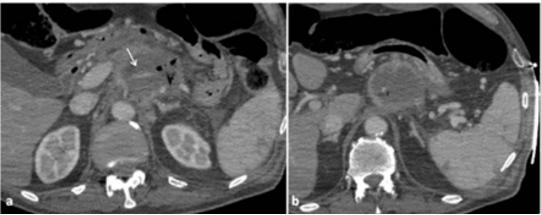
CT scan showed vasoconstriction of splenic artery (a, white arrow) associated with the presence of multiple small spleen defects of perfusion (a, b).
